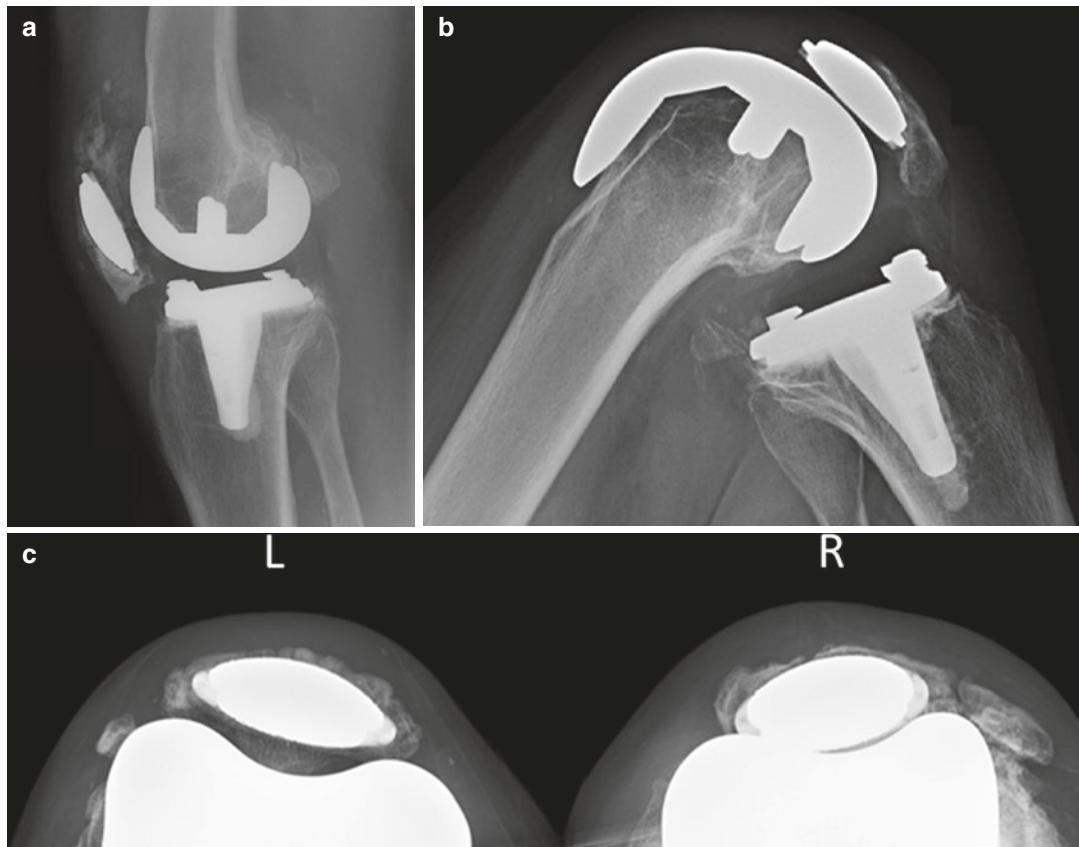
(a) Lateral radiograph of the right knee 10 years after surgery demonstrates resorption of the bone over the proximal one-third of the Trabecular Metal (TM) surface but stable position of the patellar component. (b)
